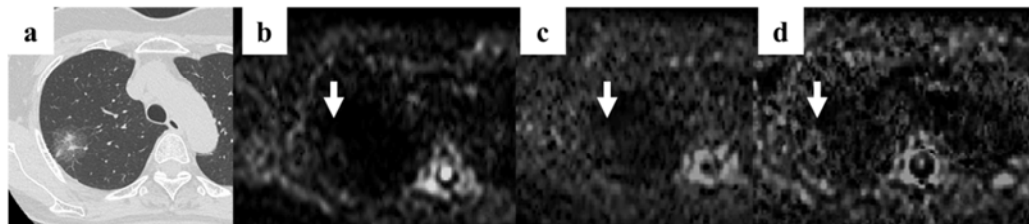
A 74-year-old female patient with adenocarcinoma in the right upper lobe. (a) CT shows a nodule in the right upper lobe. (b) aDWI with a b value of 500 s/mm² shows slightly high signal intensity; the score of detection assessment is 4 and the LSR is 0.59. This assessment identified the nodule as benign. (c) Signal intensity shown in aDWI with a b value of 1,000 s/mm² was slightly high or equal to lung parenchyma; the score of detection assessment is 3 and the LSR is 0.53. This assessment identified the nodule as benign. (d) cDWI with a b value of 1,000 s/mm² also shows high signal intensity; the score of detection assessment is 4 and the LSR is 3.06. This assessment identified the nodule as malignant.
